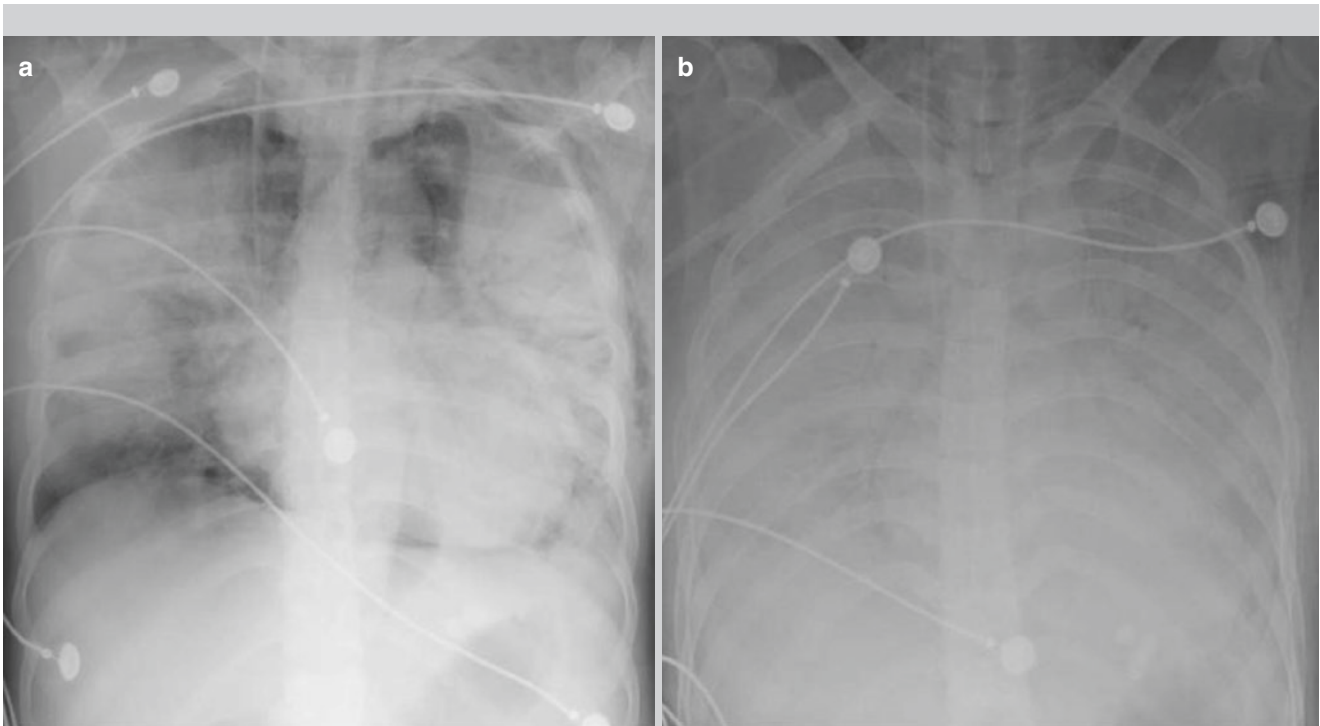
Chest X-ray demonstrated decreased transparency of both lung fields and large consolidation opacity in both lungs, with air bronchogram inside (a). Reexamination after treatment for 2 days showed
